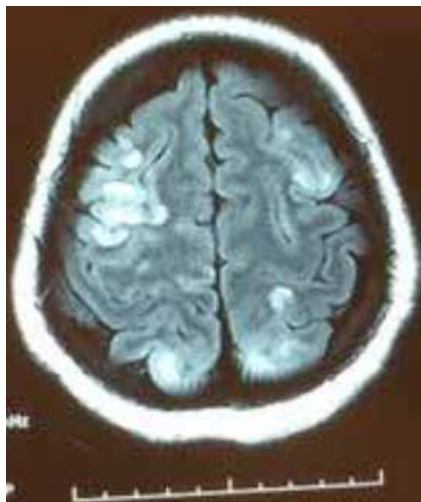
T2 Flair Axial MRI Image showing diffuse involvement of cortex
